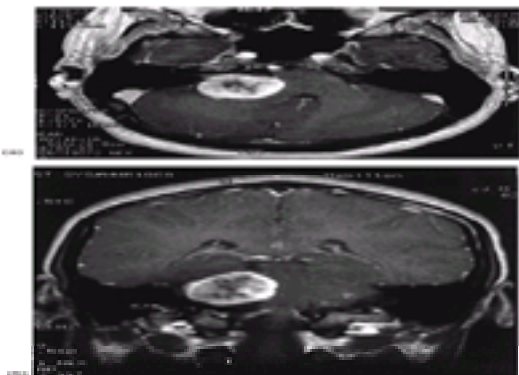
(a) Gadolinium-enhanced axial T_1 -weighted MRI of a right-sided acoustic neuroma. There is compression of the pons and cerebellum and the fourth ventricle is shifted to the left. The tumor extends into the internal auditory canal and has a heterogeneous signal internally. (b) Gadolinium-enhanced coronal T_1 -weighted MRI of the same lesion showing that the tumor extends all way up to the tentorium and occupies the usual location of the middle cerebellar peduncle.
